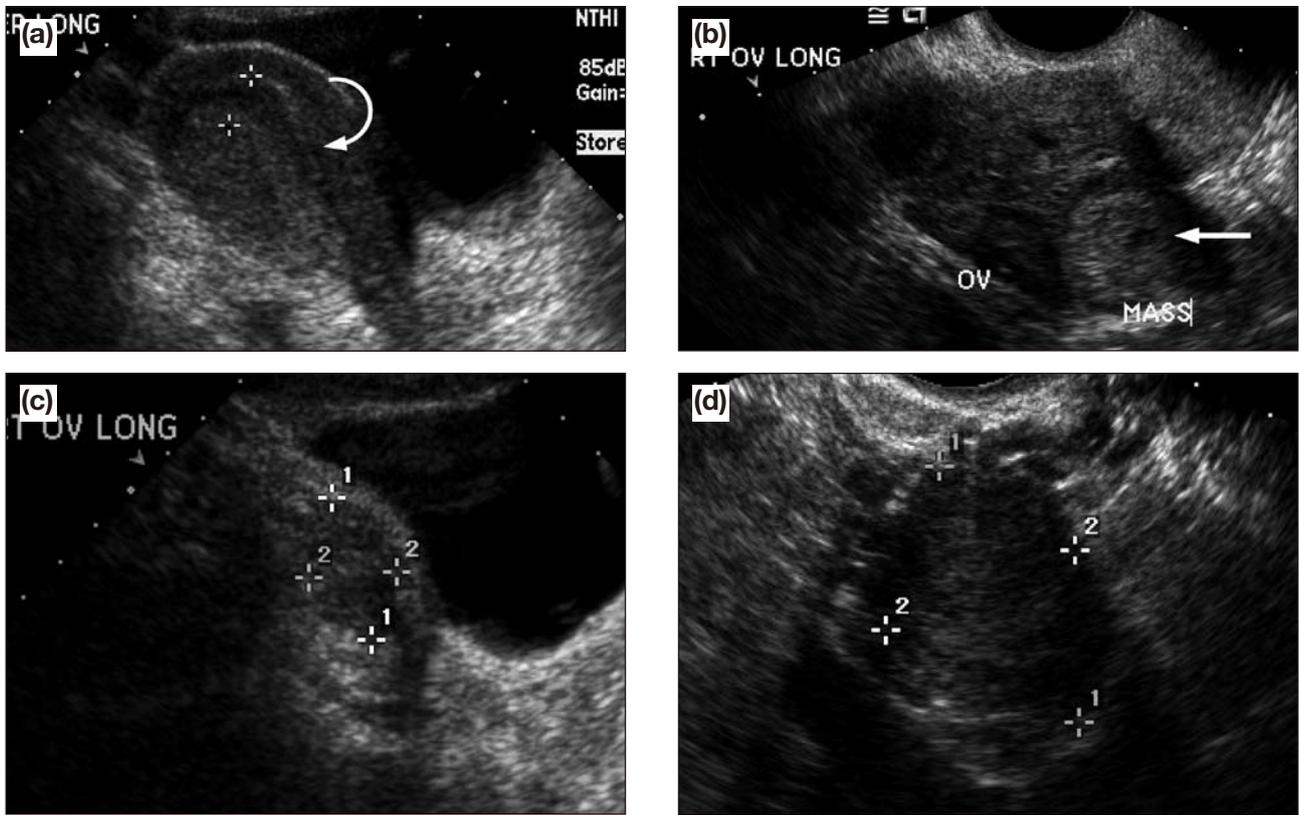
Extraovarian adnexal mass. (a) Sagittal transabdominal scan showing no evidence of intrauterine gestation and thickened endometrium (arrow); (b) transvaginal sonogram showing a right adnexal mass (arrow) separate from the right ovary with a possible gestational sac-like structure; and (c and d) normal appearing ovaries separate from the mass.
